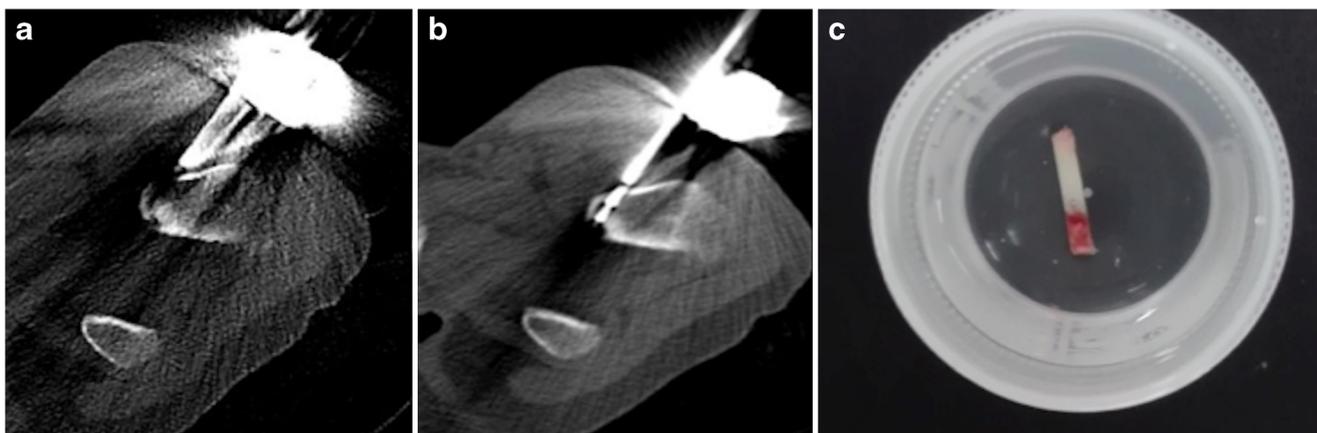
a Low-dose (spiral scan: 50 mAmp, 100 KV) CT picture confirming the position of the bone drill in the lateral aspect of the femoral neck. Note the significant artefact of the mechanical arm of the navigation system. b The inner bit of the drill was removed and a bone
